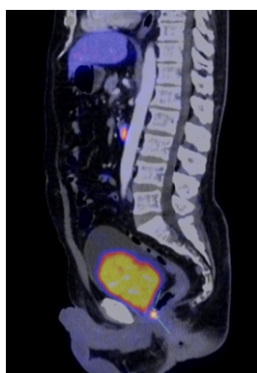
Sagittal fused ^{18}F -PSMA PET/CT image demonstrating focal intense PSMA uptake in the prostate gland consistent with prostate adenocarcinoma focus. No nodal disease or metastasis was present.
